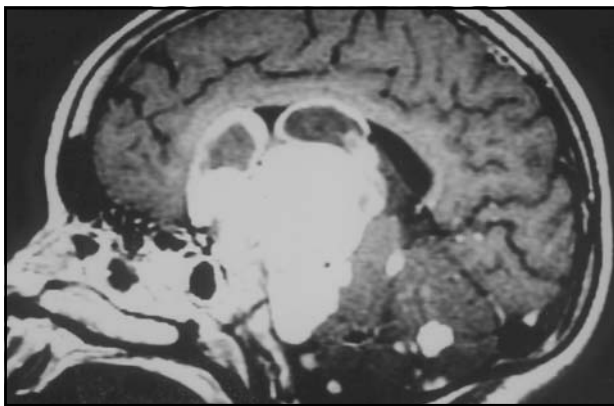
Sagittal T1-weighted MR image obtained after administration of contrast material disclosed a heterogeneous lesion at the optic nerve and chiasm with multiple tumoral implants.
